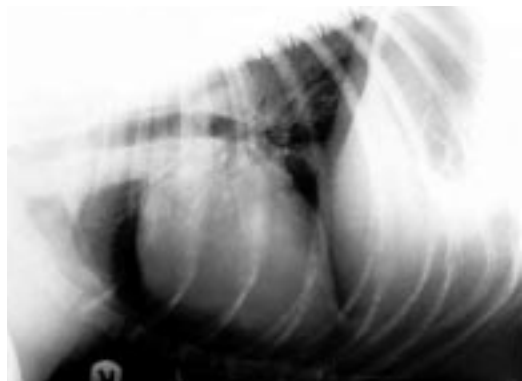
Right lateral thoracic radiograph (expiratory film): rounding of the cranial border of the cardiac silhouette. The lung fields are clear.
